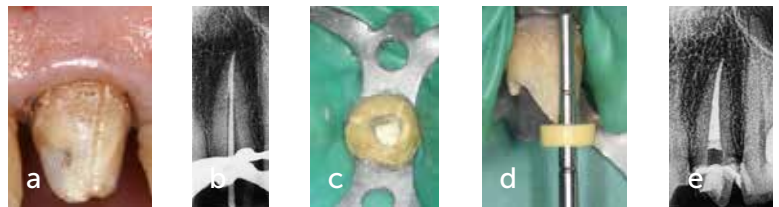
(a) View of the discolored prosthetic abutment after removal of the crown. (b) Endoral radiograph of the gutta-percha cone test. (c) Occlusal view of the GIC substrate. (d) Definition of the root area involved in the bleaching. (e) End-of-treatment radiograph showing the position of the GIC substrate.
